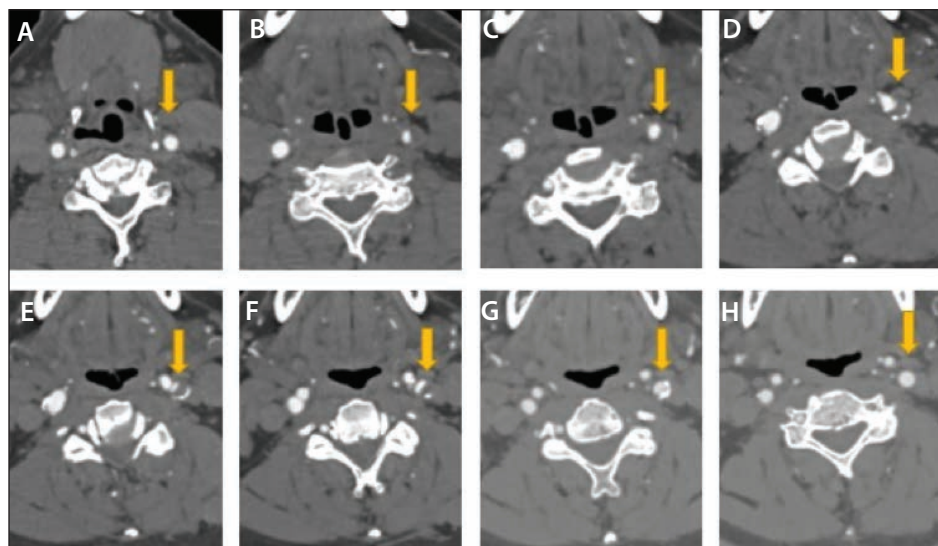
CTA depicting the left carotid stenosis (yellow arrows) from proximal (A) to distal (H). Of note, the right carotid and vertebral arteries were widely patent, and the left vertebral artery was hypoplastic. Not shown here is a hypoplastic posterior circulation secondary to the patient's previous cerebrovascular event.
